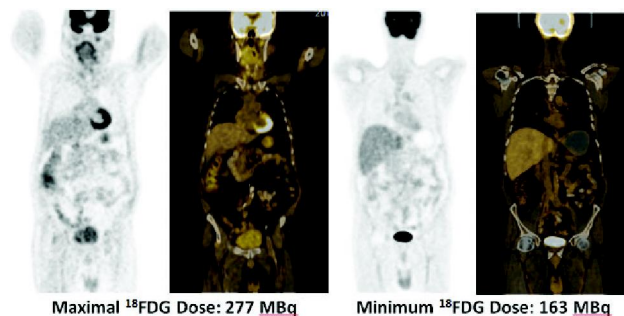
FDG PET and PET/CT images acquired with minimum and maximum injected doses of ^{18}F FDG
